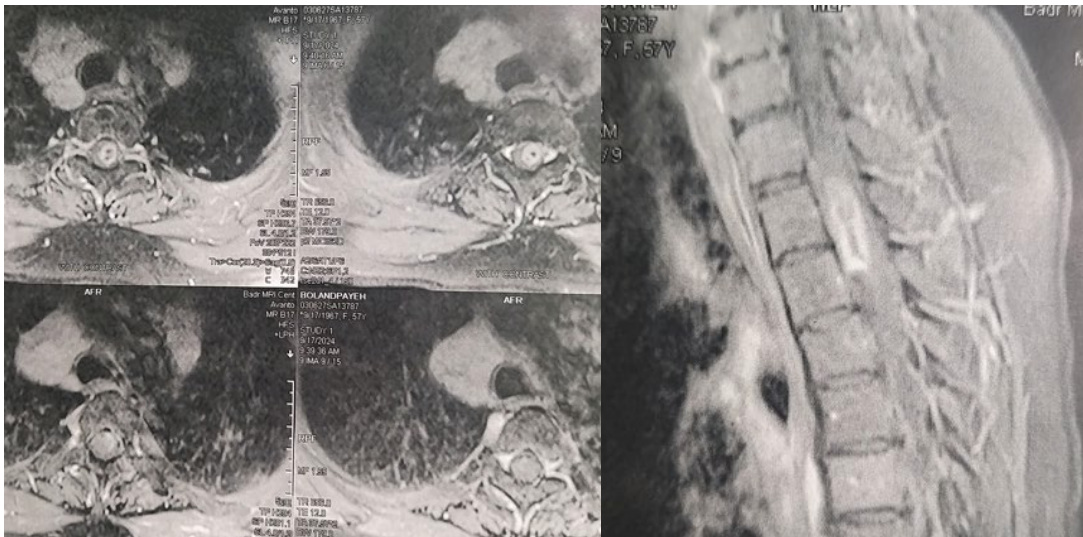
Axial (left) and sagittal thoracic MRI with contrast.
